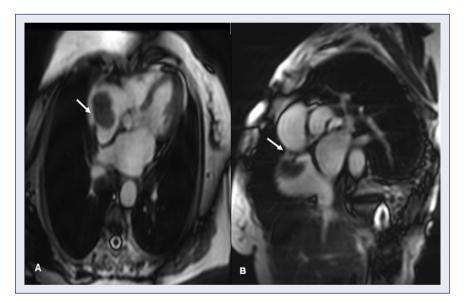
Magnetic resonance imaging showing a mass attached to the right atrium with pedunculus (arrow).
